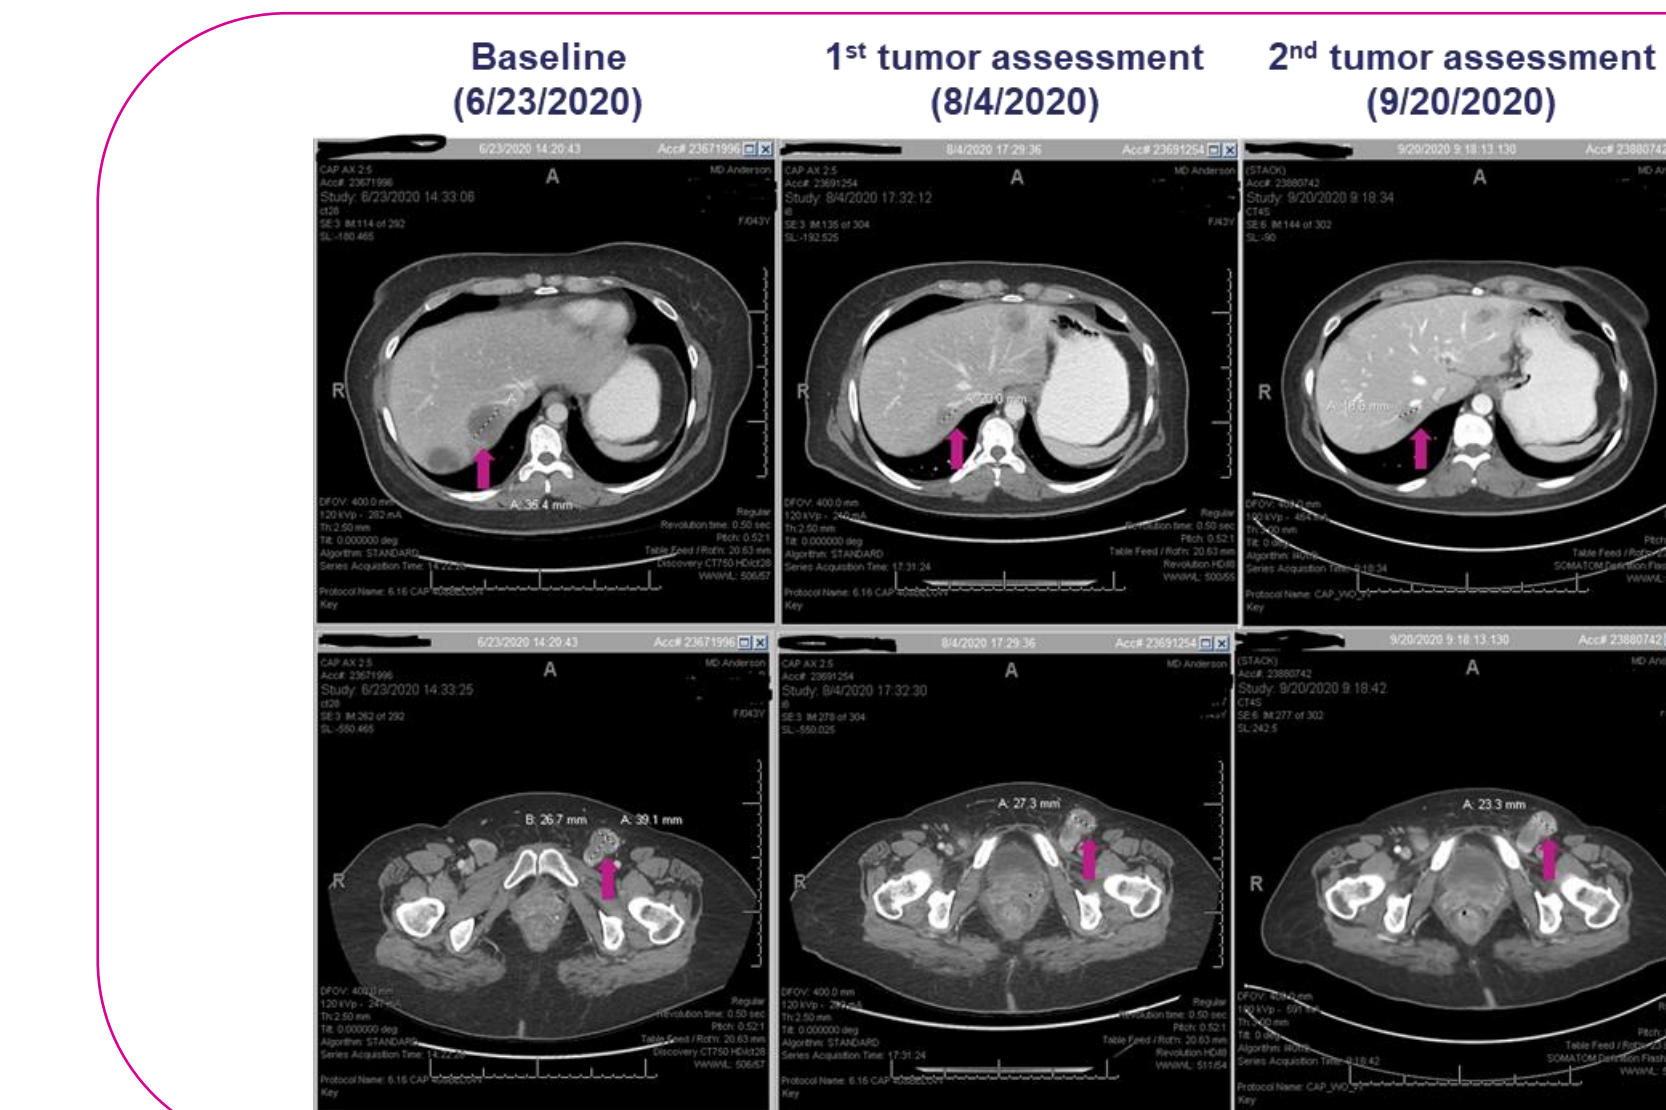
Representative CT scans from the patient with metastatic mucosal melanoma who achieved a confirmed PR
